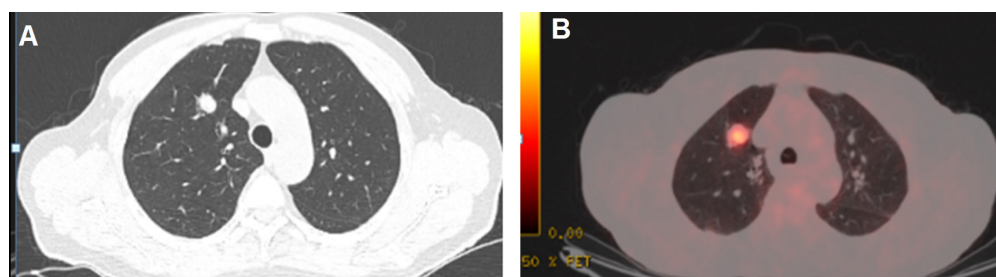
(A) Thorax computed tomography shows a solitary pulmonary nodule with a diameter of 2 cm in the right upper lobe. B) Pathologic increased uptake of ^{18}F -FDG on positron emission tomography/ computed tomography is seen (SUV_{max} : 5.9).
